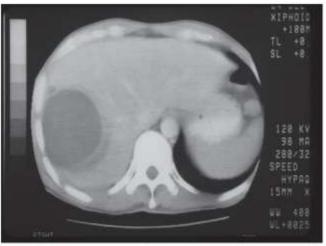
Noncontrast computed tomography image demonstrating rightsided amoebic liver abscess in a patient presenting to care in Toronto, Ontario, after international travel. The abscess is homogenous and single, which is a typical finding
